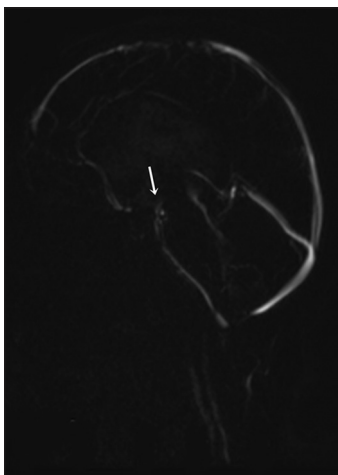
Sagittal cine phase-contrast magnetic resonance imaging after 5 years. Continuous (patent) cerebrospinal fluid flow from the foramen of Monro to the prepontine cistern (white arrow) and aqueductal flow are observed
